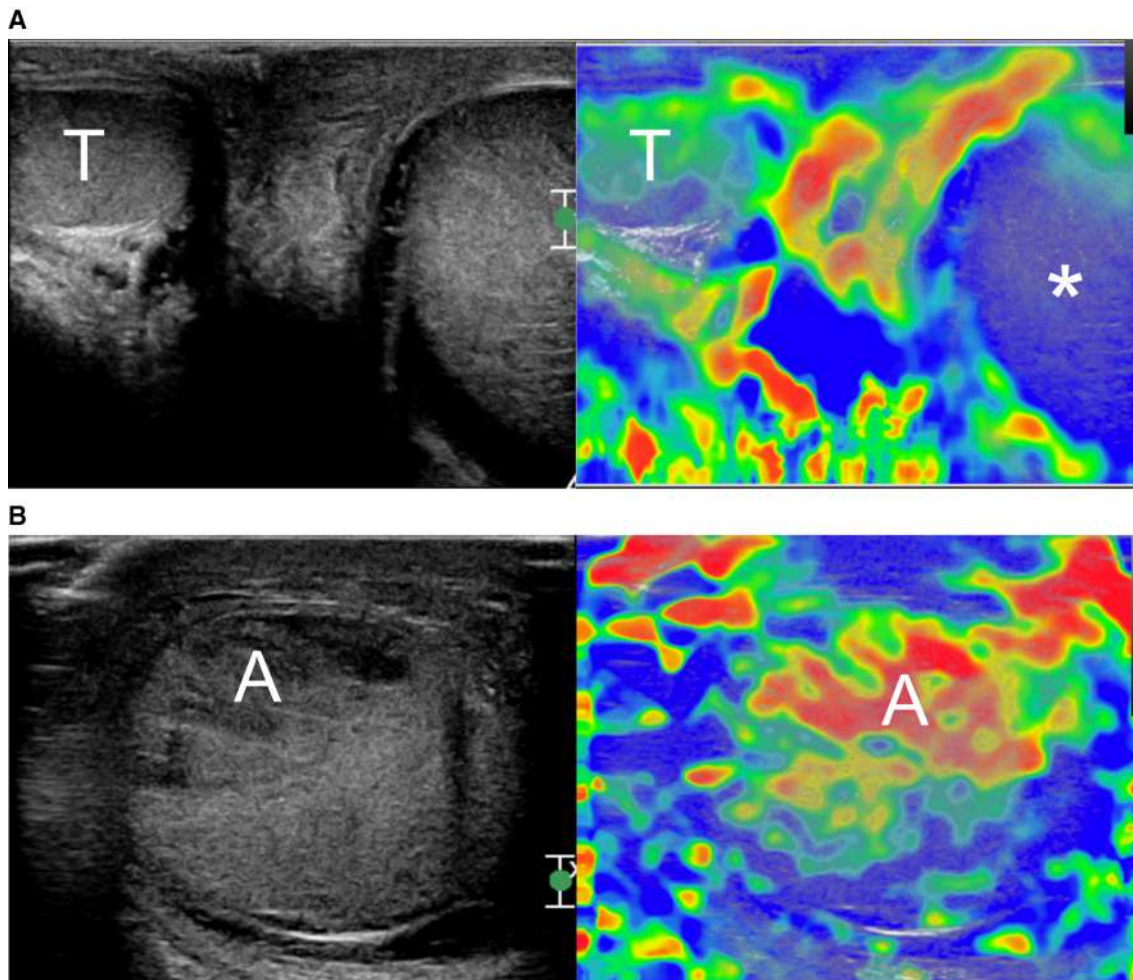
Severe epididymo-orchitis in a patient presenting with right testicular pain and swelling. “Spectacle” view of both testes obtained with a transverse plane. A Color Doppler ultrasonography reveals a hypoechoic hypervascular right testis (T). The contralateral left testis (asterisk) displays normal vascularity. B Strain elastography axial image showing a
